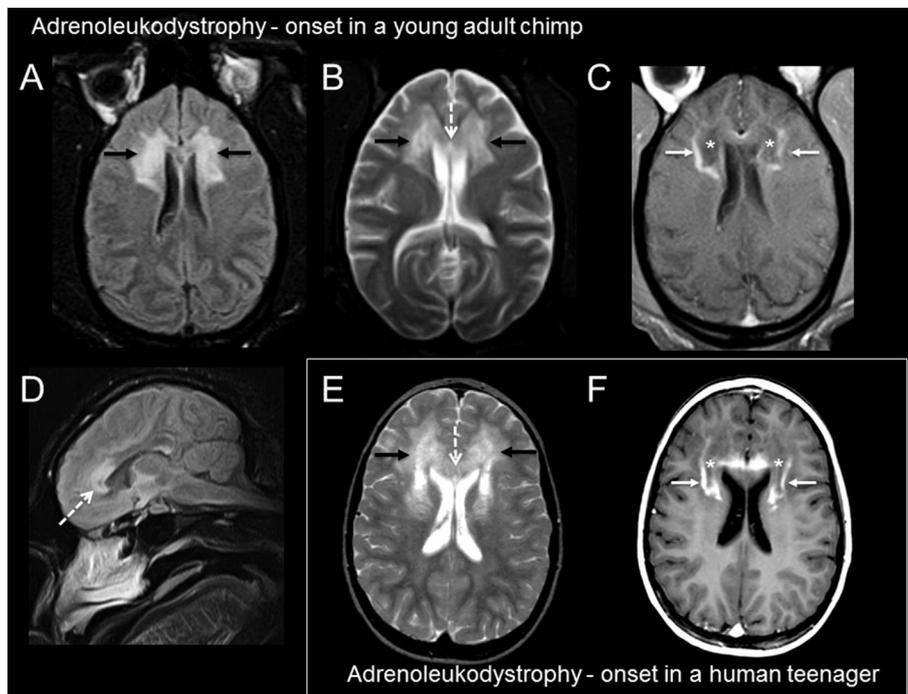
MR in Adrenoleukodystrophy (ALD): Axial and mid-sagittal FLAIR imaging (A and D, respectively), axial T2-weighted images (B, E), and axial post-gadolinium-enhanced T1-weighted images (C, F) in the chimpanzee (A–D) and human (E, F). Note abnormal, relatively symmetric, bilateral, frontal lobe white matter hyperintensity on the FLAIR and T2-weighted images in both individuals (black arrows). Involvement of the genu of the corpus callosum is demonstrated on B, D, and E (dotted white arrows). Hypointensity of the central portion of the white matter lesion is noted on the T1-weighted images (asterisks), and contrast enhancement of the advancing edge of the lesion (white arrows) are typical for actively demyelinating X-ALD. While involvement of the parieto-occipital white matter, including the splenium of the corpus callosum, predominates in childhood onset X-ALD, initial involvement of the frontal region, including the genu of the corpus callosum, is characteristic of juvenile and adult patients with X-ALD.
